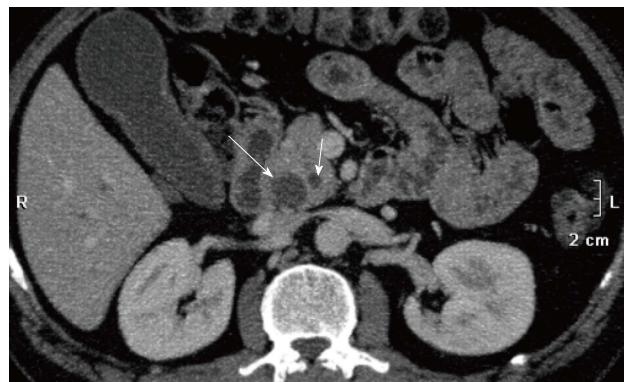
Double duct sign in a 52-year-old male with ampullary adenocarcinoma. Contrast-enhanced CT scan shows dilatation of the main pancreatic duct (short arrow) and common bile duct (long arrow).
